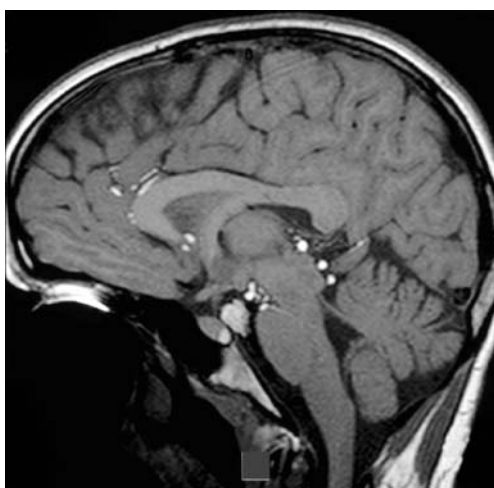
Sagittal MRI (T1-WI) of an intra-, supra- and parasellar dermoid (Patient 2); spilling of fatty particles into the basal cisterns, ambient cistern, intraventricular and subarachnoid space with adhesion to the basilar artery
